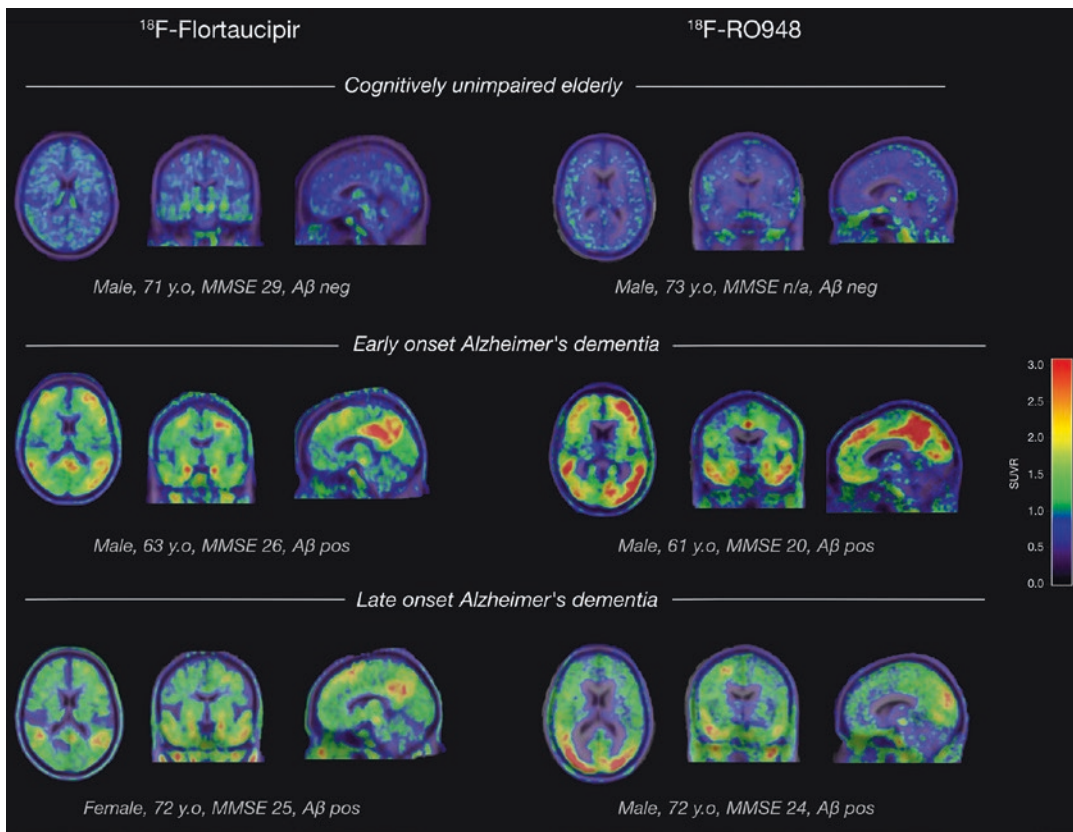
Representative ^{18}F -flortaucipir (80–100 min) and ^{18}F -RO948 (60–90 min) PET SUVR images in cognitively unimpaired older individuals (upper row) and patients with early-onset Alzheimer's disease (EOAD) (<65 years) and late onset AD (rows two and three, respectively). ^{18}F -Flortaucipir images (80–100 min SUVR) are courtesy of the Alzheimer's disease neuroimaging initiative (ADNI); ^{18}F -RO948 images were kindly provided by Roche (Drs. Gregory Klein and Edilio Borroni) and Drs. Dean Wong and Hiroto Kuwabara from Johns Hopkins
